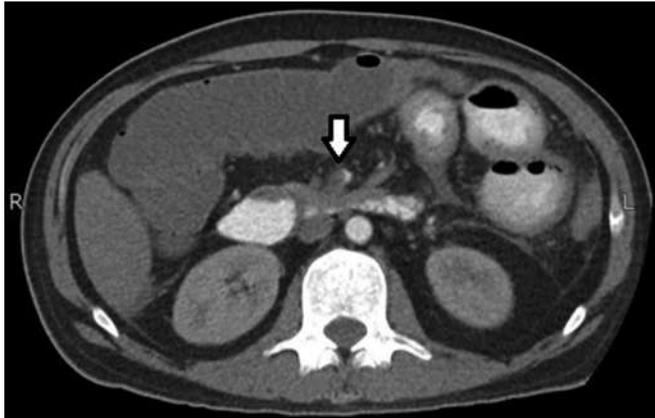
Axial post-contrast arterial phase CT image shows dilated thick-walled small bowel loops in left mid abdomen showing fat stranding in the adjacent mesentery, suggestive of ischemic loops. Note the partial thrombus in SMA (arrow).
